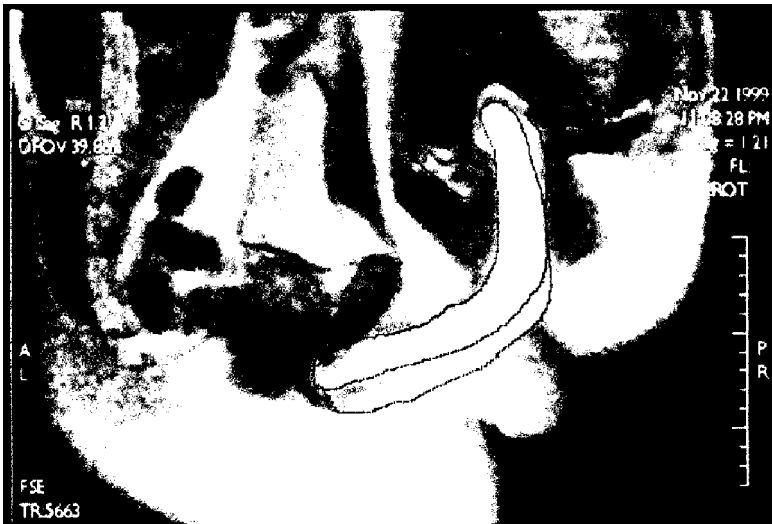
MRI second session (missionary position)
